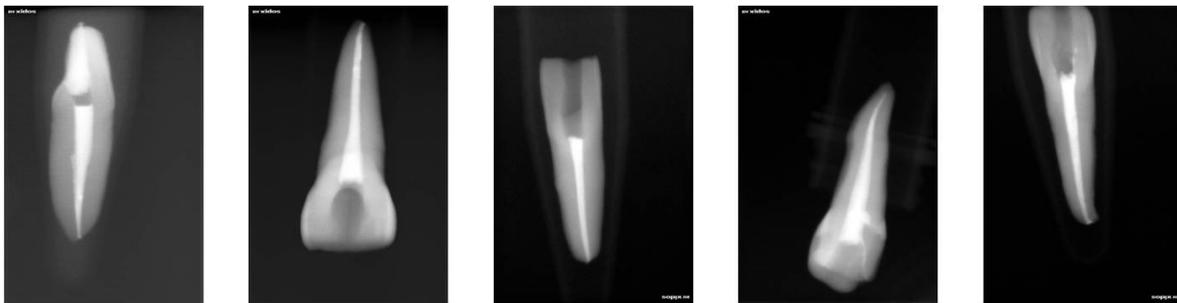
Radiographs of the endodontic space, confirming the adequacy of the root filling.
